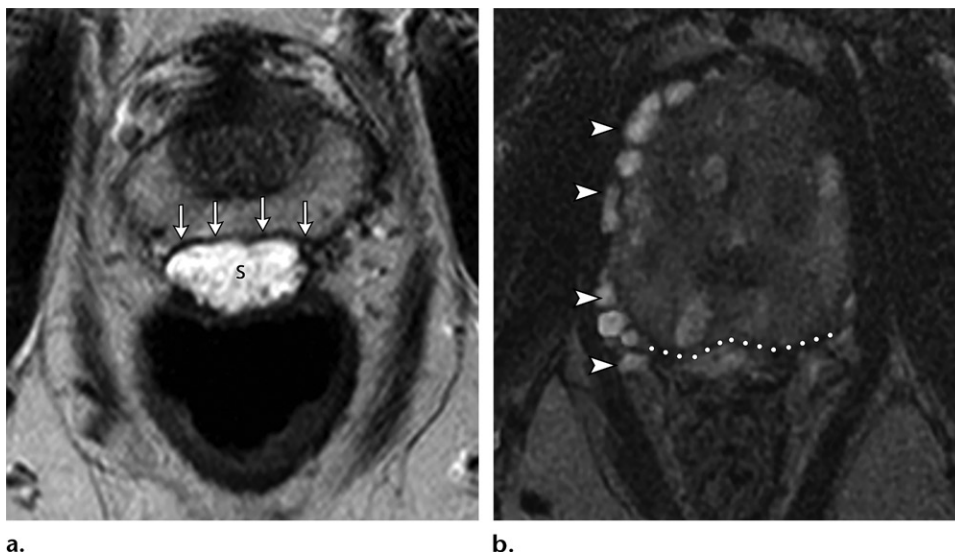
Successful and unsuccessful spacer injection between the Denonvillier fascia and the posterior rectal wall in two men. (a) Axial T2-weighted MR image in a 61-year-old man shows successful spacer injection between the rectal wall and Denonvillier fascia (arrows) to separate the rectal wall (posterior) from the prostate gland (anterior) in an attempt to minimize toxicity during prostate radiation therapy. The Denonvillier fascia can be seen as a dark line just anterior to the high-signal-intensity injected spacer (S). (b) Axial T2-weighted MR image in a 62-year-old man shows the spacer injected into the periprostatic vessels (arrowheads), which is a potential complication that occurs when the spacer is injected anterior to the Denonvillier fascia (dotted line).
